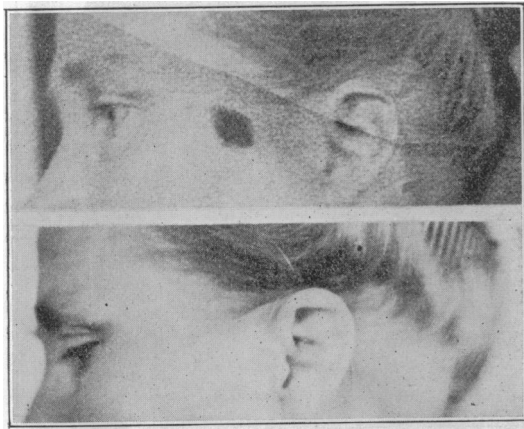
Pigmented Tumor of Cheek before and after X-Ray treatment.
